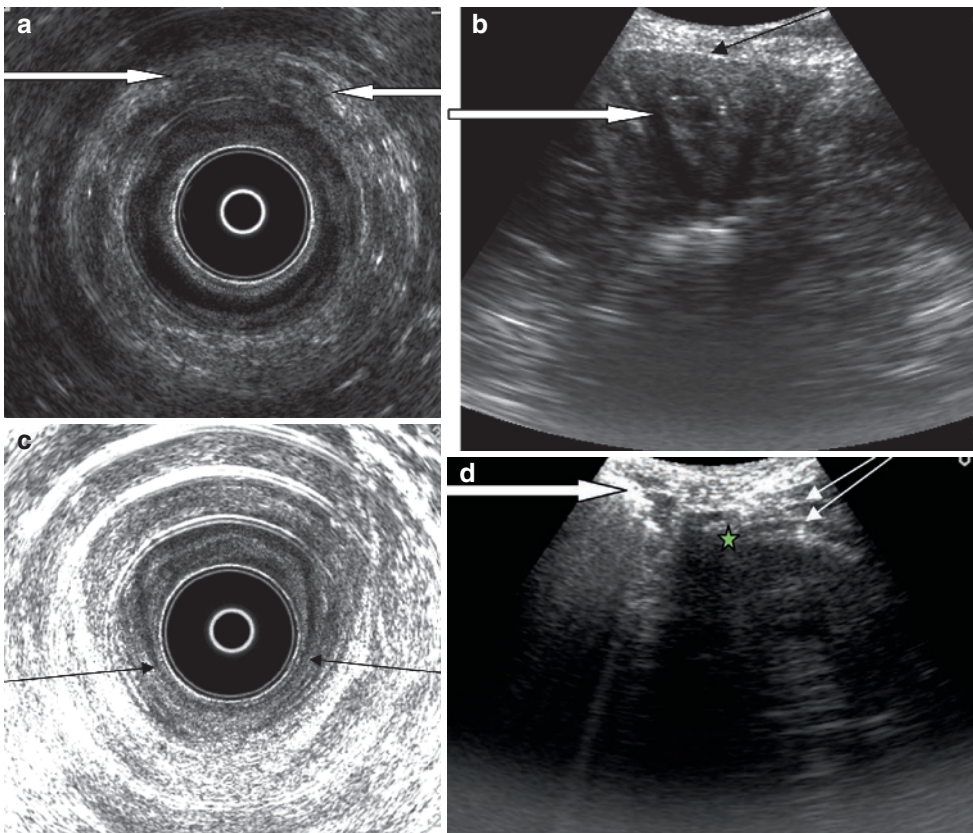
(a) Endoanal ultrasound confirming patchy external anal sphincter defect secondary to destructive perirectal sepsis (*arrows*), (b) Axial trans-perineal ultrasound showing thinned external anal sphincter (*arrows*). The internal anal sphincter is shown as the hypoechoic layer (*block arrow*), (c) Evidence of internal anal sphincter damage posteriorly
